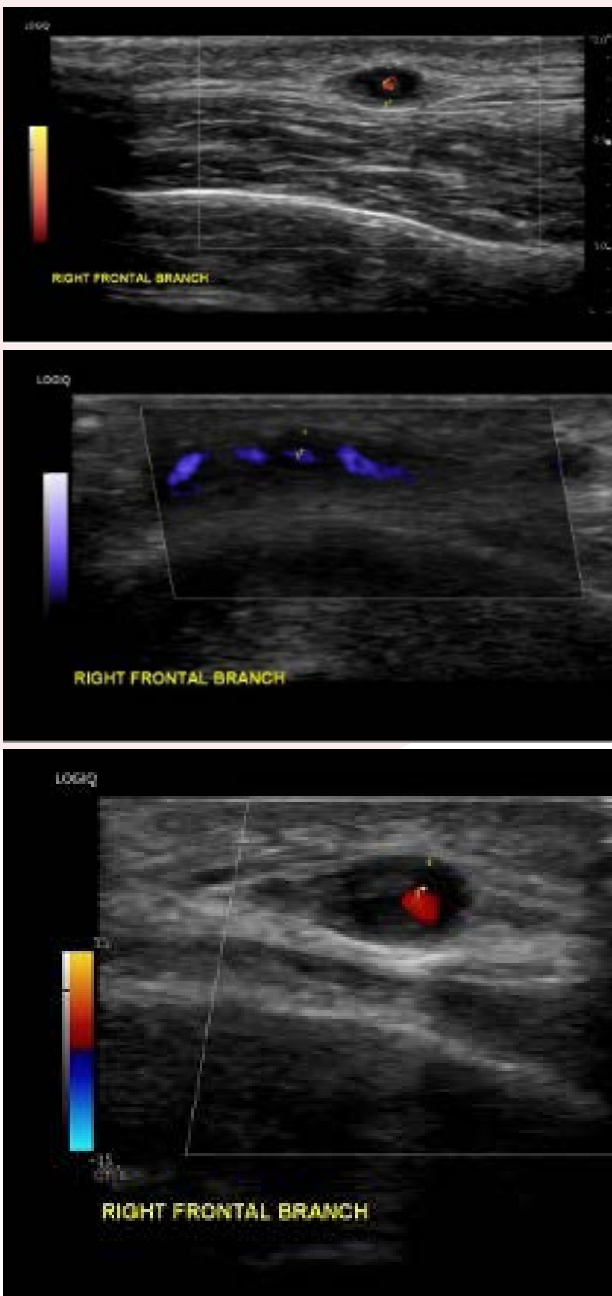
Right Frontal Branch of the Temporal Artery in both transverse and longitudinal plane, visualised with a high-frequency hockey stick probe (6-24 MHz). The image demonstrates a thickened incompressible hypoechoic ring around the patent lumen captured with Power Doppler Imaging (PDI), Microvascular Imaging (MVI) and Colour Doppler.
